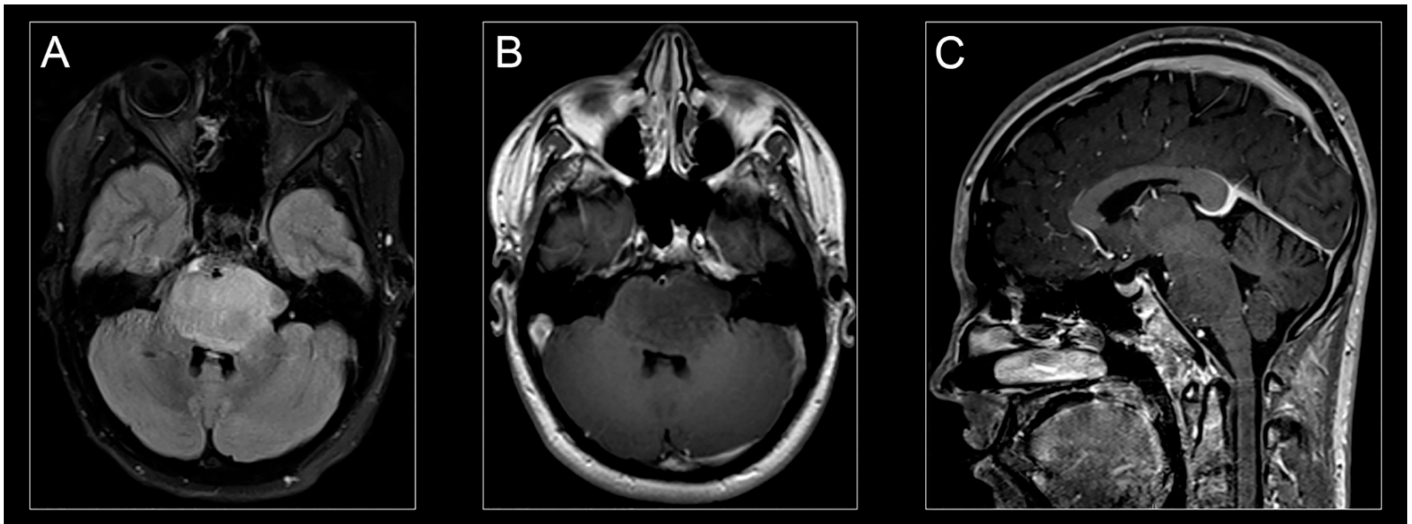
H3K27M-mutant diffuse midline glioma on MR imaging. Classic appearance of H3K27M-mutant diffuse midline glioma on MR-imaging: hyperintense signal on an axial T2-weighted fluid-attenuated inversion recovery (FLAIR) image (A), hypointense signal on an axial T1-weighted post-contrast image (B), and isointense signal on a sagittal T1-weighted post-contrast image (C).
